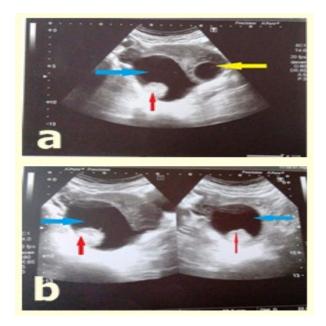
(a,b). Ultasonographic picture of the case showing ovarian cyst (yellow arrow) and paraovarian cystic structure (blue arrow) with a solid component (red arrow). Note. The paraovarian cyst is close to but clearly separated from the ipsilateral ovary
